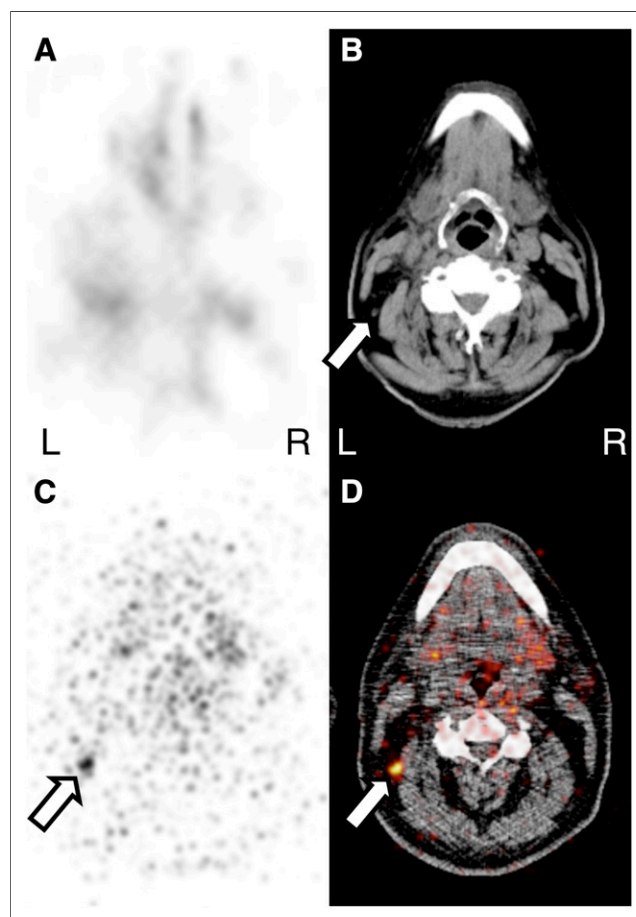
Patient with iodine-positive right nuchal lymph node metastasis (focus 1, arrows) detected by early ¹²⁴I PET/CT but not by ¹³¹I SPECT/CT. Shown are axial cervical SPECT (A) and SPECT/CT (B) images, along with their corresponding PET (C) and PET/CT (D) images.
